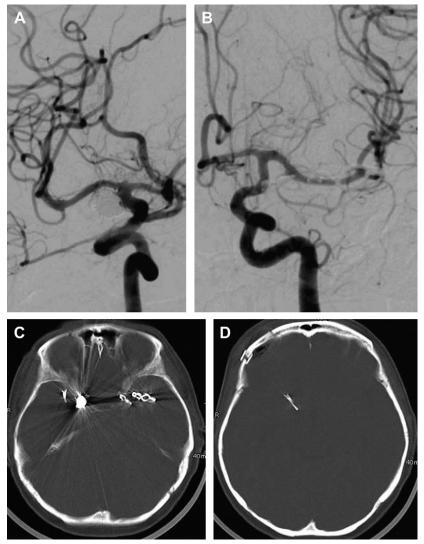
Cerebral angiography following clipping of (A) all ipsilateral right-sided and (B) all contralateral left-sided aneurysms; CT image showing (C) all clips inserted from the right side and (D) the right-sided supraorbital keyhole craniotomy.
